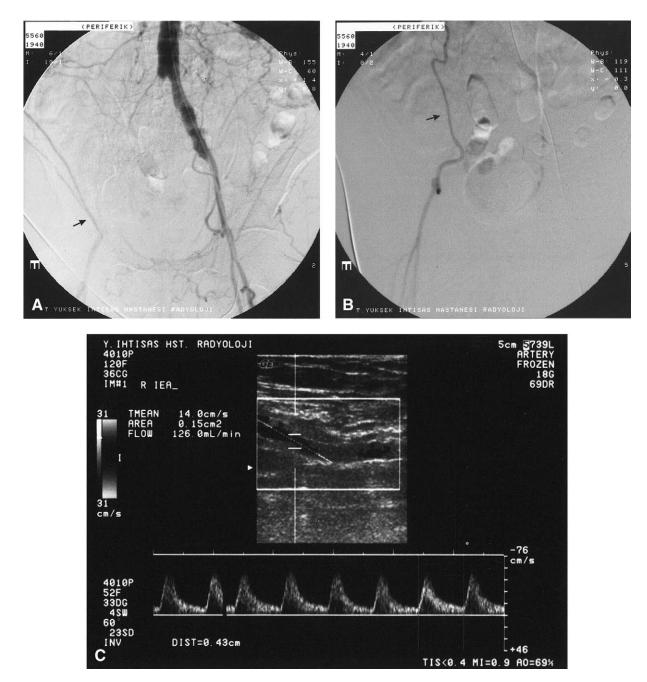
Right common iliac artery occlusion in a 65-year-old man. A, Abdominal aortogram reveals occlusion of right common iliac artery. There is faint reconstitution of the distal external iliac artery on the right via the deep circumflex iliac artery (*arrow*) that is due to partial washout of contrast material by unopacified blood from the ipsilateral of the internal thoracic artery-inferior epigastric artery (ITA-IEA) collateral. B, Selective angiography of the right subclavian artery demonstrates anastomosis between the ITA-IEA (*arrow*) via the superior epigastric artery, reconstituting the right external iliac artery. C, Color duplex ultrasonography shows monophasic spectral pattern in the IEA. The flow was measured as 126 mL/min in the IEA and 262 mL/min in the femoral artery, the contribution of the ITA-IEA collateral to lower-extremity perfusion is calculated to be 48%.
